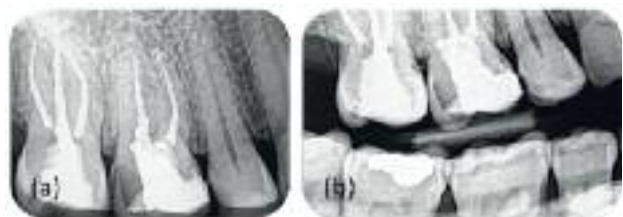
(a) Periapical radiograph of tooth #3 revealed a previous endodontic treatment and a possible missed disto-buccal root canal. (b) Bite-wing radiograph provided more precise information about the condition of the pulp chamber.
